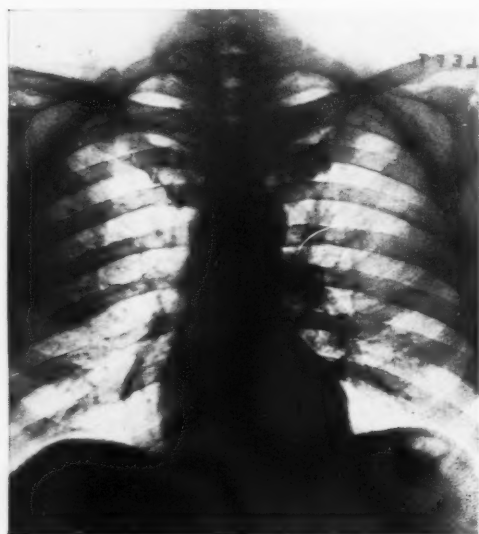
Radiograph made later in which left hilus shadow is still definitely accentuated and linear markings in median portion of left lung are still increased. Mottling in upper lobe has completely disappeared.
